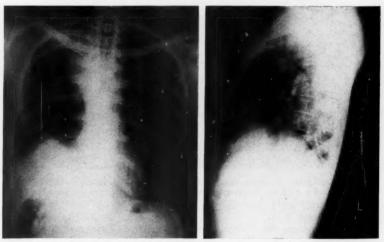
a and b. Posteroanterior and lateral chest films 3 months postoperatively and 1 month following completion of x-ray therapy.
